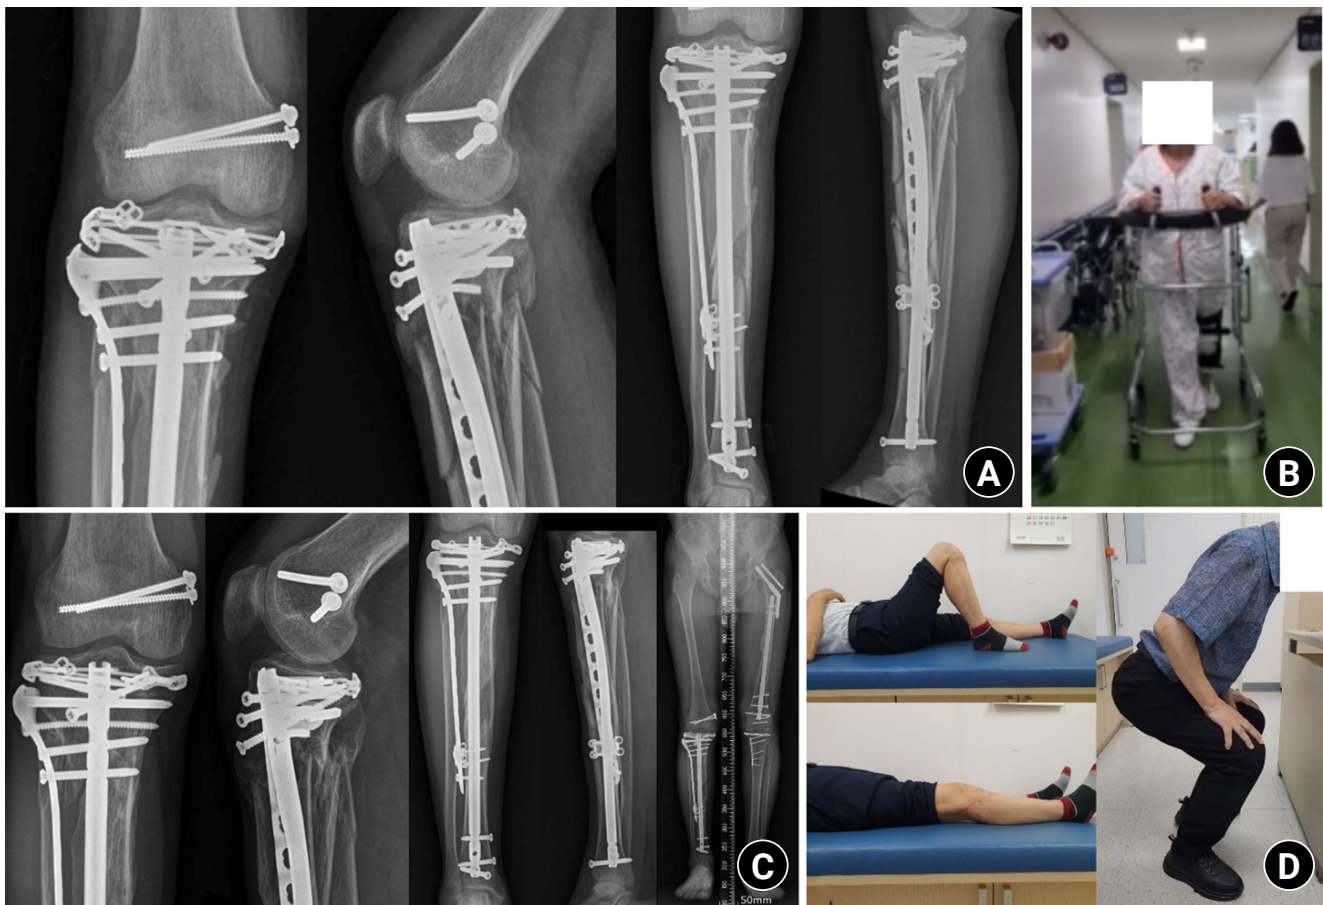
Follow-up plain radiographs and clinical photographs taken 6 weeks and 1 year after surgery. (A) Plain radiographs 6 weeks postoperatively. (B) Clinical photograph showing the patient ambulating with a walker 6 weeks after surgery. (C) Plain radiographs taken 1 year postoperatively. (D) Clinical photographs 1 year after surgery showing good knee joint range-of-motion and the ability to perform squatting exercises.
